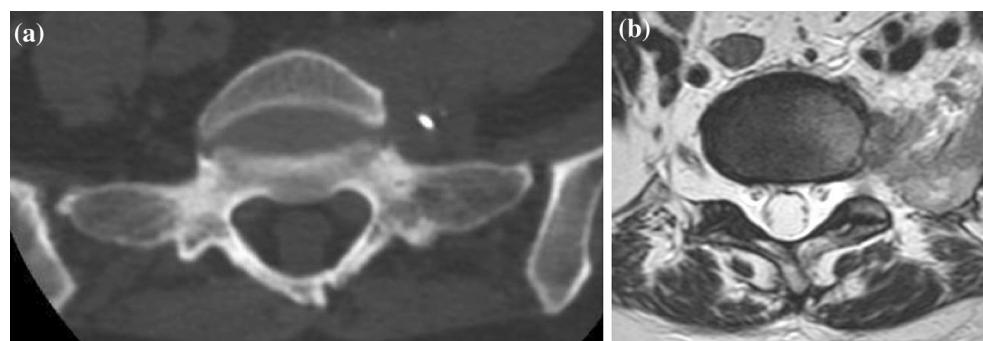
Postoperative CT scan (a) and MRI (b) confirming the complete removal of the osteophyte
